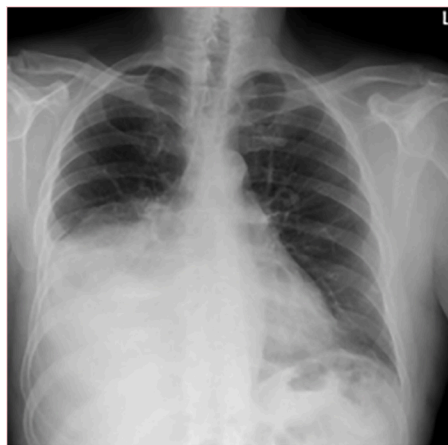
Chest X-ray (First admission).
